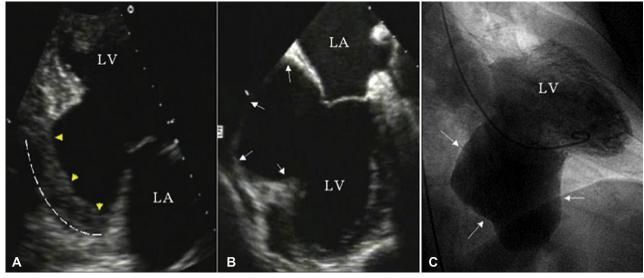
Transthoracic echocardiography shows the inferolateral aneurysm (A, white dotted line) occupied by thrombotic stratification (yellow arrows) and confirmed by transesophageal study (B, white arrows). Preoperative left ventricular angiography shows the extent of the aneurysmatic sac (C, white arrows) and its independence from the cardiac cycle. LA, Left atrium; LV, left ventricle.
